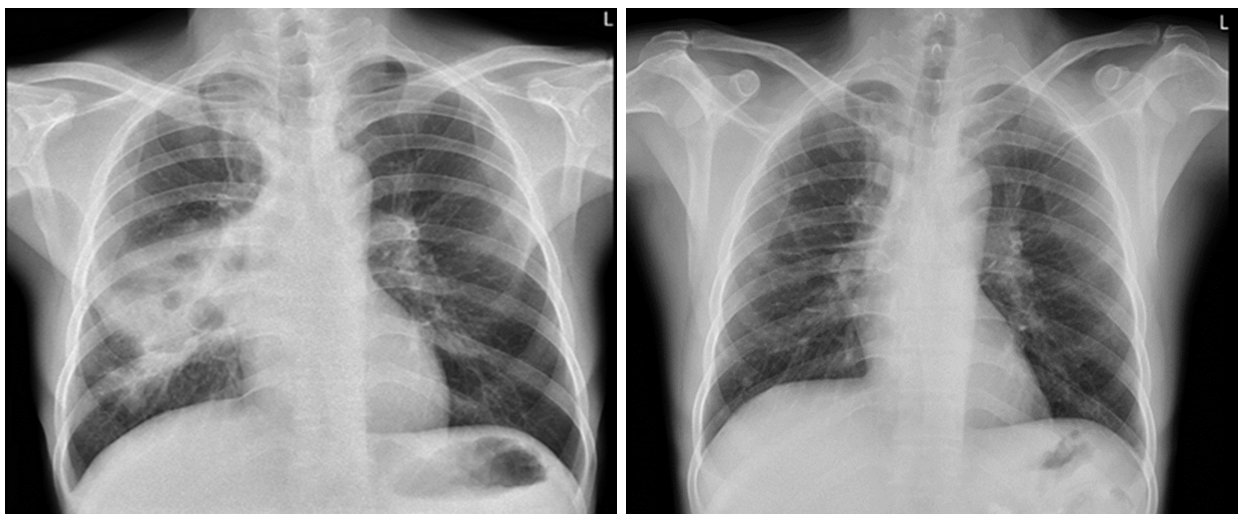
Chest X-ray before (left) and after (right) anti-TB treatment.
